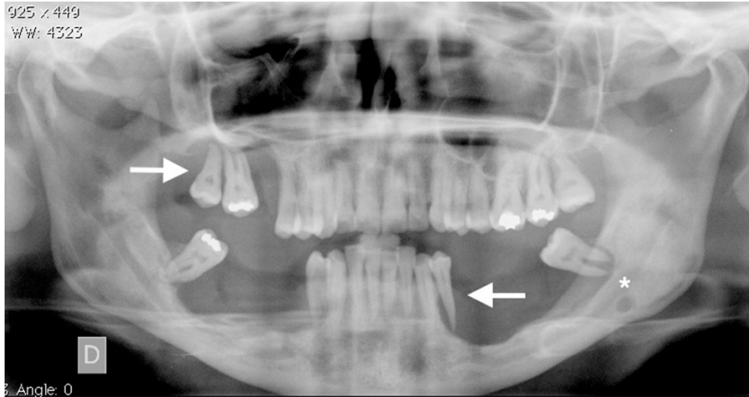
Panoramic radiograph showing the aggressive nature of the LCH. Severe bone destruction and the characteristic floating teeth appearance are evident (arrows), while a radiolucent lesion can be seen at the left angle of the mandible (star). This analysis was performed three years after the initial examination.
